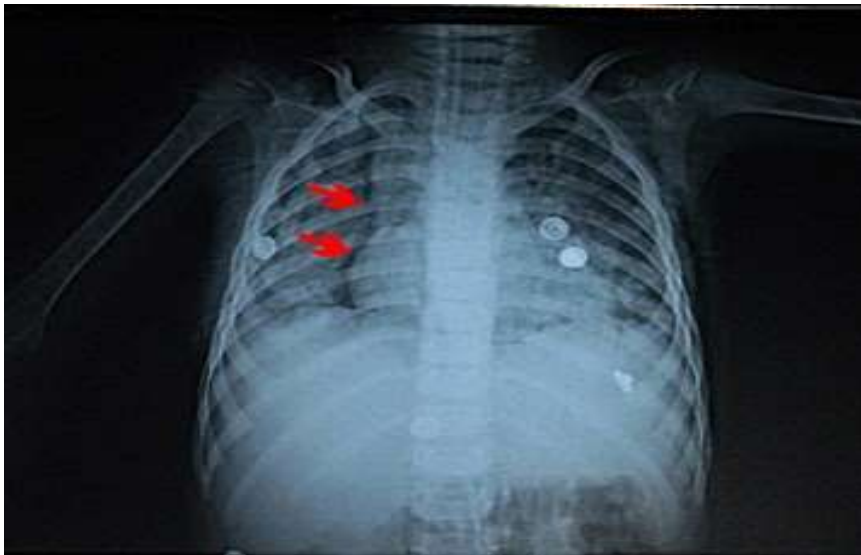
Radiograph of plain x- ray chest (antero-posterior view) of female child with corrosive poisoning showing right sided pneumo-mediastinum (red arrows) indicating air in mediastinum.
